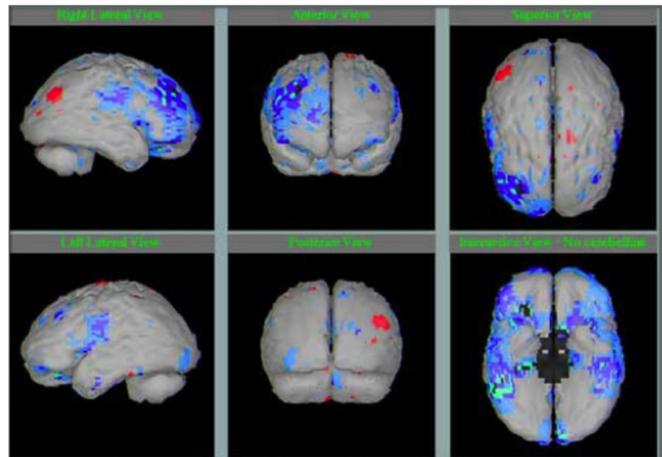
Typical ME brain SPECT demonstrating diffuse brain hypoperfusion injury as seen in either a viral or toxic chemical injury. Where the image is darkest (deep blue online) there is significantly decreased brain function (activity and/or injury). Where it is grey, there is a disturbance of function. Most patients tend to have consistent injuries in the primitive cortex (under the brain mass, lower right). This zone has several purposes, including coordinating abilities and the manufacture of essential enzymes and enabling chemicals, immune factors and hormones, to name just a few. Depending upon the location of the injuries, different intellectual, physical and immune characteristic changes may occur in the injured patient.
